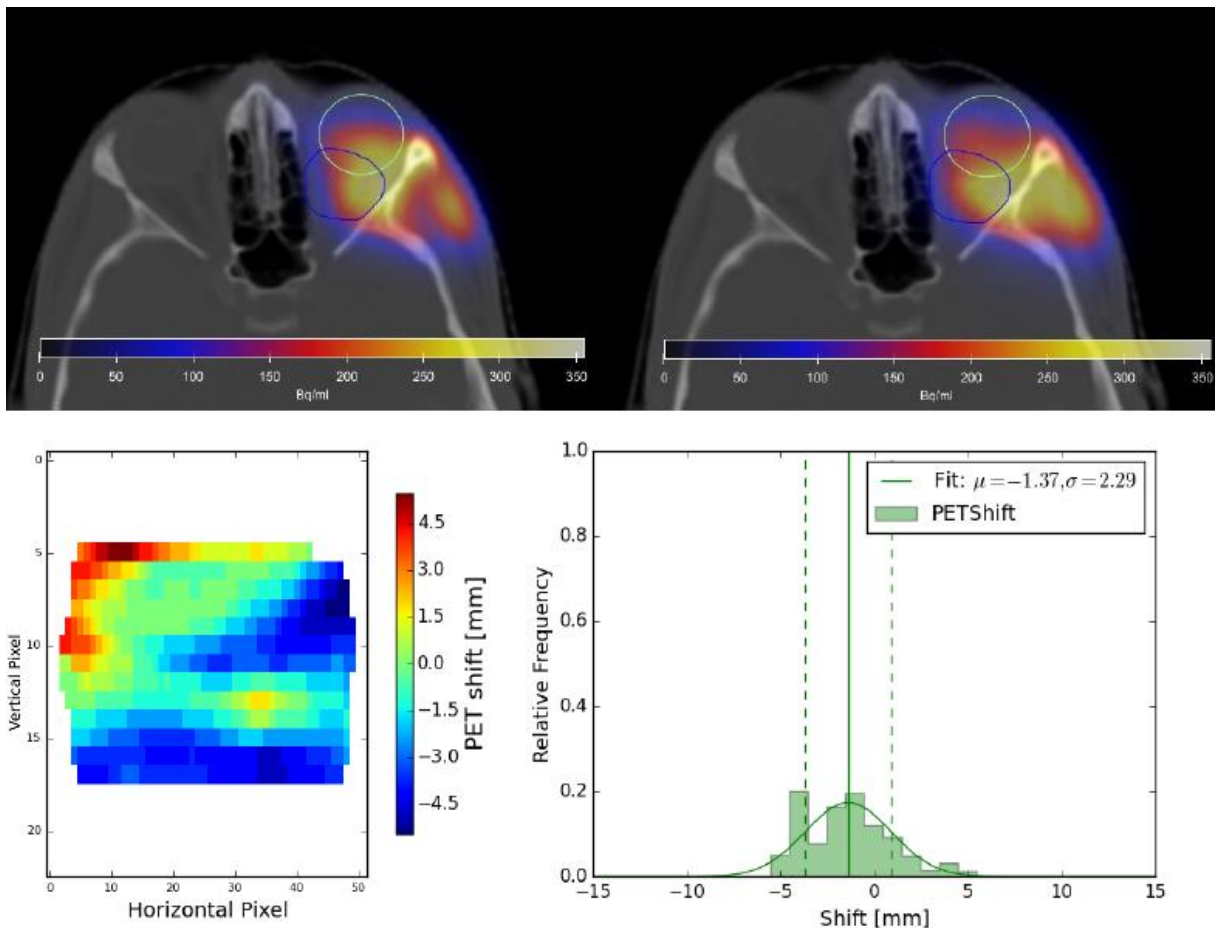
PET predictions from MC FLUKA on measured CT (from acquired PET/CT) (top panel left) and PET/CT measurement (top panel right) for a patient case, and corresponding analysis of the PET range difference through a BEV map (bottom left) and associated histogram (bottom right) (Handrack 2016).
